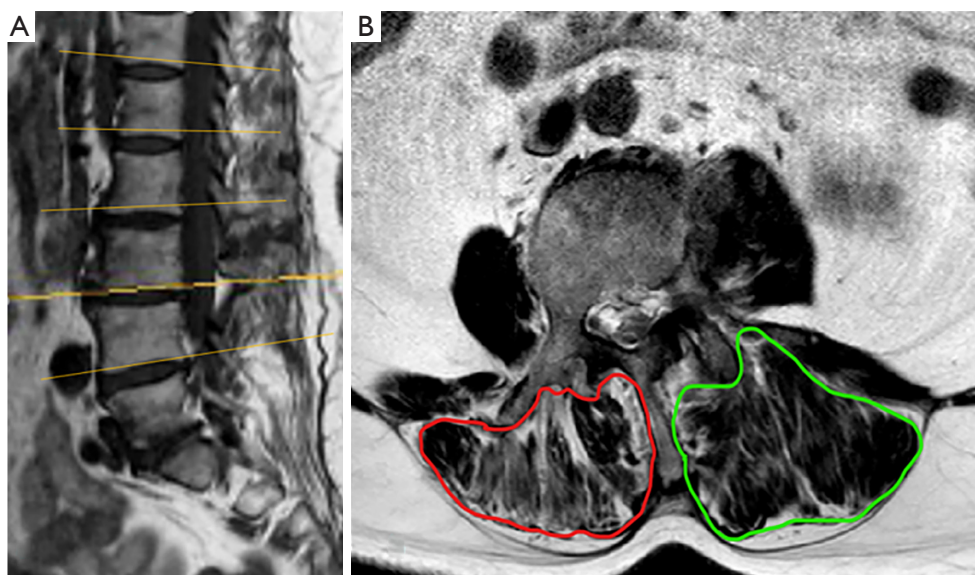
Sagittal (A) and trans-axial (B) MRI image. Yellow lines show the levels evaluated in this study and the area circled by red line shows paraspinal muscle in convex side and green line demonstrates the paraspinal muscle in concave side of the curve. MRI, magnetic resonance imaging.
